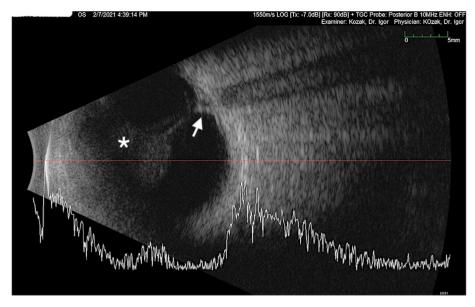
Ultrasound B-scan of the left eye demonstrates vitreous hemorrhage (white star) and epipapillary structure connected to the vitreous hemorrhage (white arrow).
